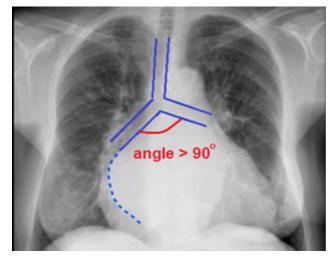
Chest X-ray of the thorax. PA view. Left atrial dilation. Angle between the right main bronchus and the left main bronchus > 90.
